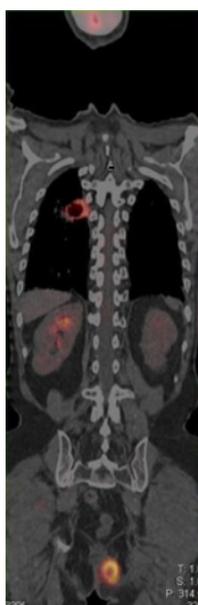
PET/CT images of the body show a mass in the right lung, adrenal mass on the right side, and mass in the left ischioanal fossa with radiotracer uptake
